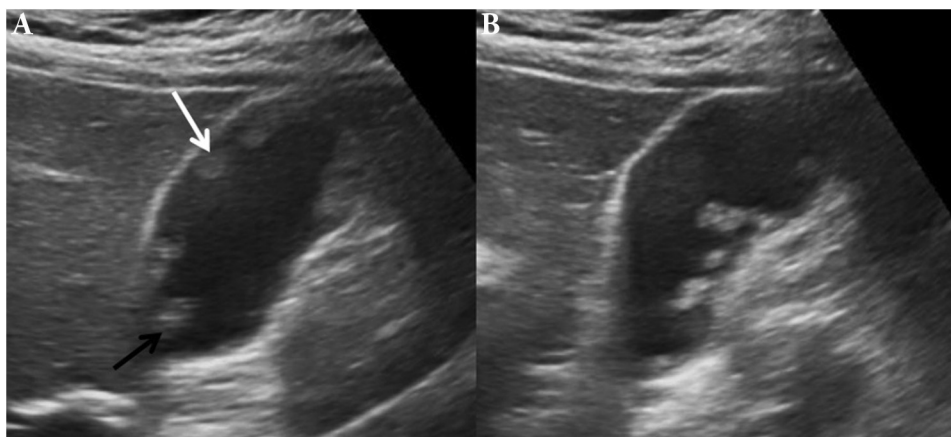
Different sonographic presentations of cholesterol polyps (A). Hypoechogenic homogeneous polyps (white arrow) and polyps with hyperechoic foci (black arrow) within one patient (B). Heterogenous polyps.
